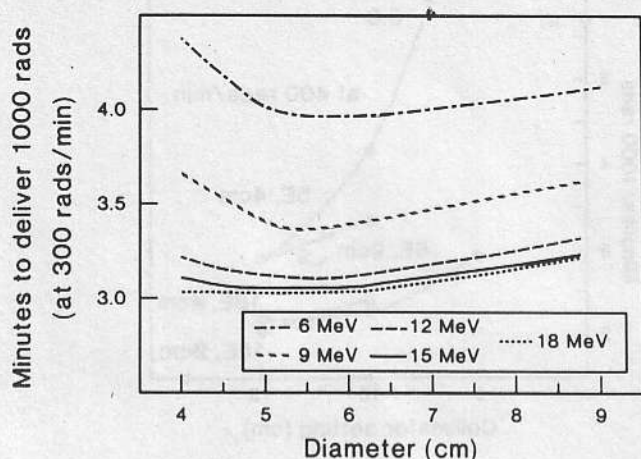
Time to deliver 1000 rads given dose (at 300 MU/min) as a function of circular applicator diameter and nominal electron-beam energy. Data are for flat end applicators and 10×10 cm² x-ray collimator jaw setting.
